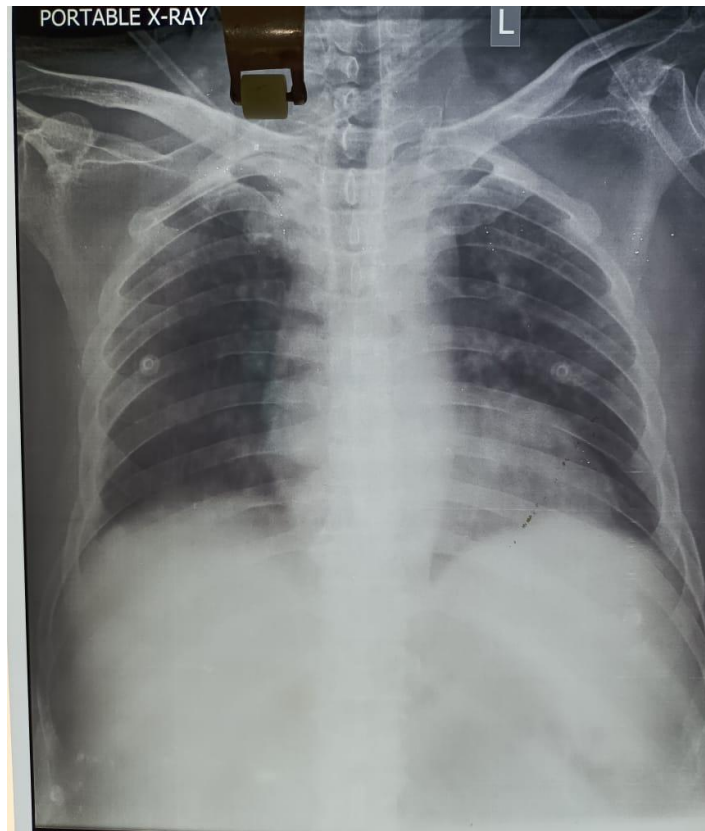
Follow-up chest radiograph showing significant radiological improvement.
